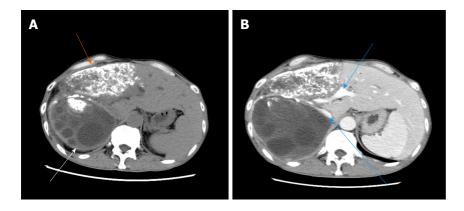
The typical case of abdominal enhanced computed tomography. A: The low-density shadow indicated by the white arrow is cystic echinococcosis with multiple different sizes of subcysts inside, while the high-density shadow indicated by the orange arrow is alveolar echinococcosis, which exhibited patchy calcification; B: The high-density shadows indicated by the blue arrows are the retrohepatic inferior vena cava and portal vein.
